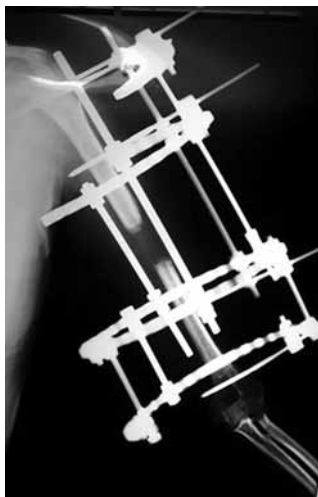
(d): Plain radiograph of left humerus of the same patient with distraction of corticotomy site & no evidence of union
